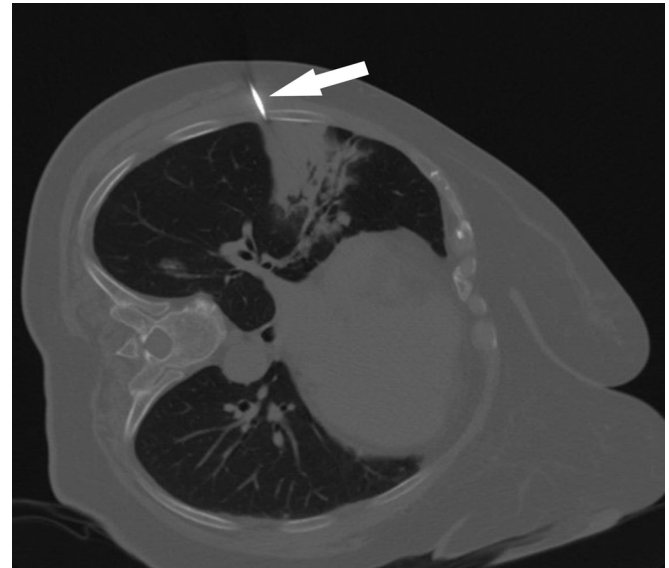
Axial CT scan of mass on the left lung in patient is presented. The outer cannula of a co-axial biopsy device is inserted within the lesion. (white arrow)
